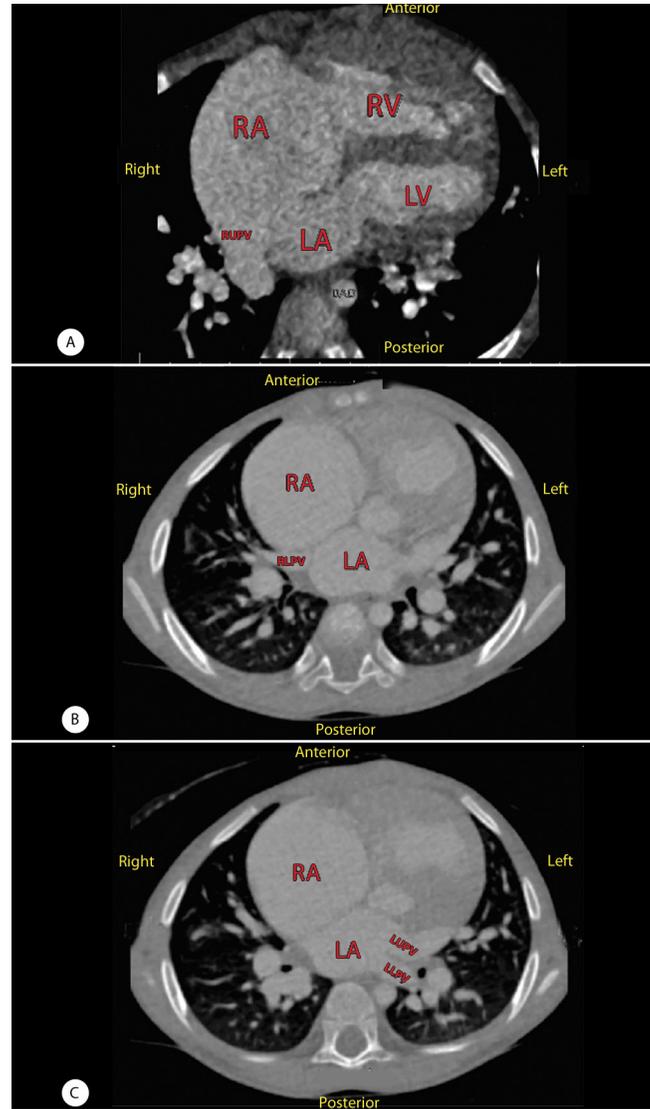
Computed tomographic angiography images of the patient revealed a normal connection of the right lower pulmonary vein and the left upper and lower pulmonary veins into the left atrium. Additionally, these images identify anomalous drainage of the right upper pulmonary vein into the right atrium, occurring at the site of the atrial septal defect.
